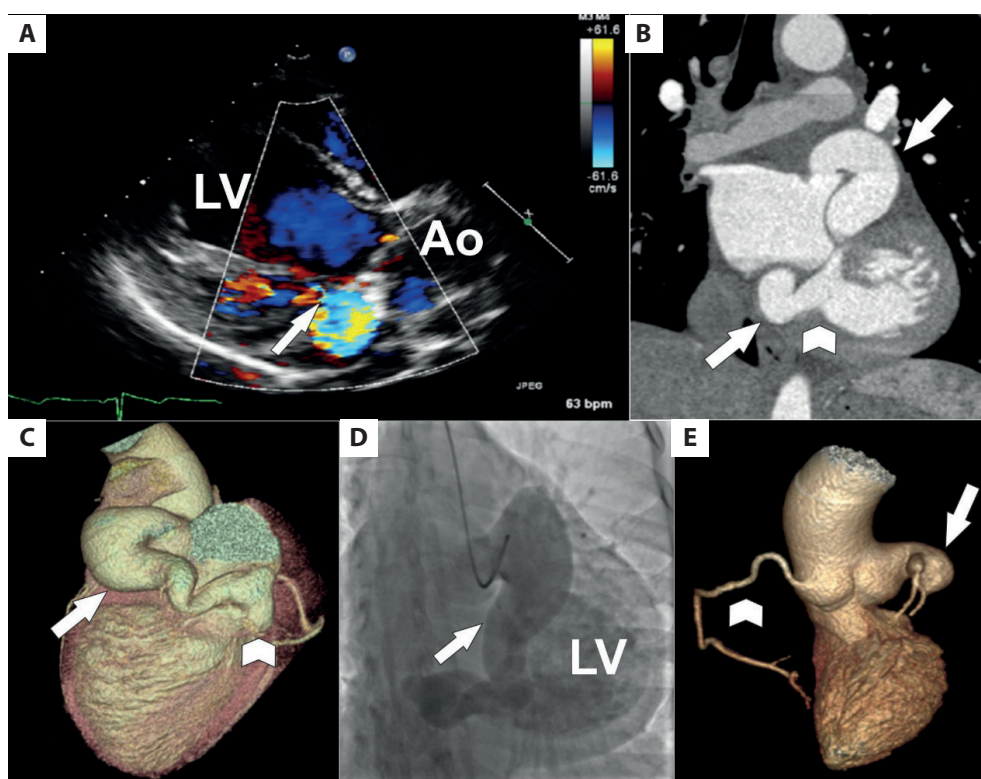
Clinical images of a 42-year-old woman with a left circumflex artery (LCx) to left ventricle (LV) fistula. A. TTE parasternal long axis view showing a hemodynamically significant shunt from the LCx to the LV chamber just under the mitral valve posterior leaflet (arrow shows shunt jet). B. CT angiography curved multiplanar reconstruction showing an ectatic and tortuous LCx (arrow) draining into the LV (arrowhead shows draining site). C. CT angiography volume-rendering reconstruction showing the ectatic and tortuous LCx (arrow) draining into the LV (arrowhead denotes draining site). D. Specialized LCx (arrow) invasive angiogram showing the ectatic and tortuous LCx with evidence of communication with the LV because of concomitant opacification of the LV by contrast media. E. CT angiography volume-rendering reconstruction (LV and ascending aorta reconstruction) showing the ligated LCx (arrow) without signs of shunting
